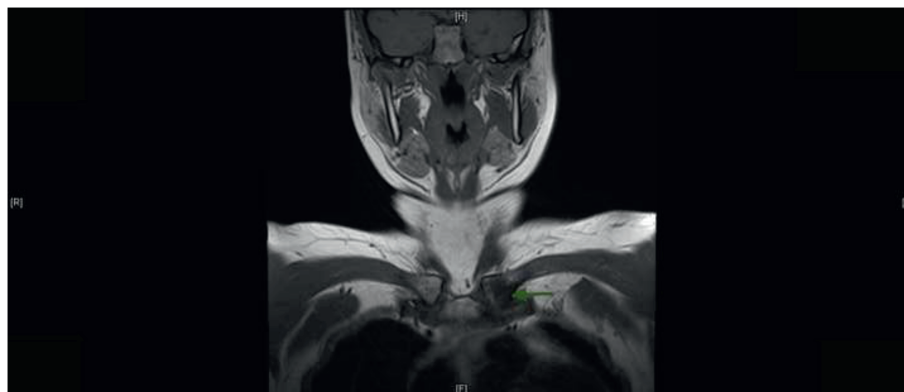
MRI scan: Abnormal signal present in T1W image in the proximal clavicle as well as the adjacent sternum (green arrow). No obvious soft tissue proliferation identified and no adjacent lymph enlargement.
